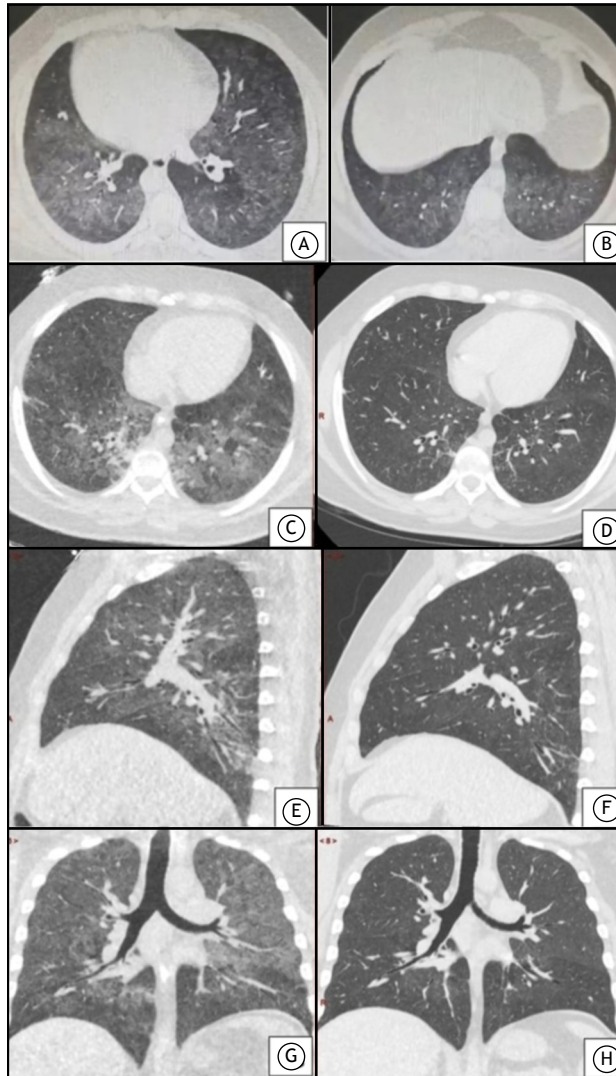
In A and B, axial CT scans of the chest of a male patient hospitalized with e-cigarette, or vaping, product use-associated lung injury. In C and D, axial CT scans of the lower lobes. In E and F, sagittal CT scans. In G and H, coronal CT scans. The scans on the left (E and G) were performed two days after extracorporeal membrane oxygenation removal, and the scans on the right (F and H) were performed two days before hospital discharge.
